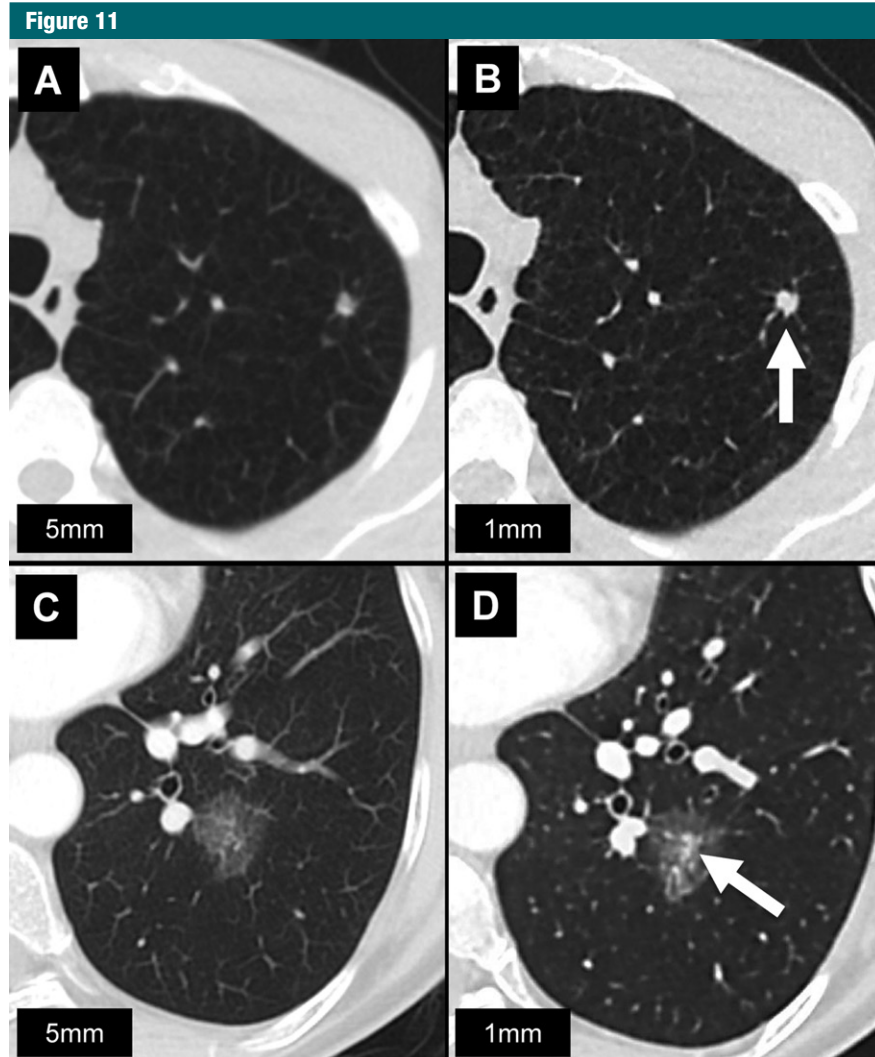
Transverse CT sections at the level of, *A, B*, a solid nodule (arrow) in the left upper lobe and, *C, D*, a part-solid nodule (arrow) in the left lower lobe. Solid and part-solid nodule margins are less well defined on *A* and *C* than on *B* and *D*. In addition, *D* better shows solid nodule components.
